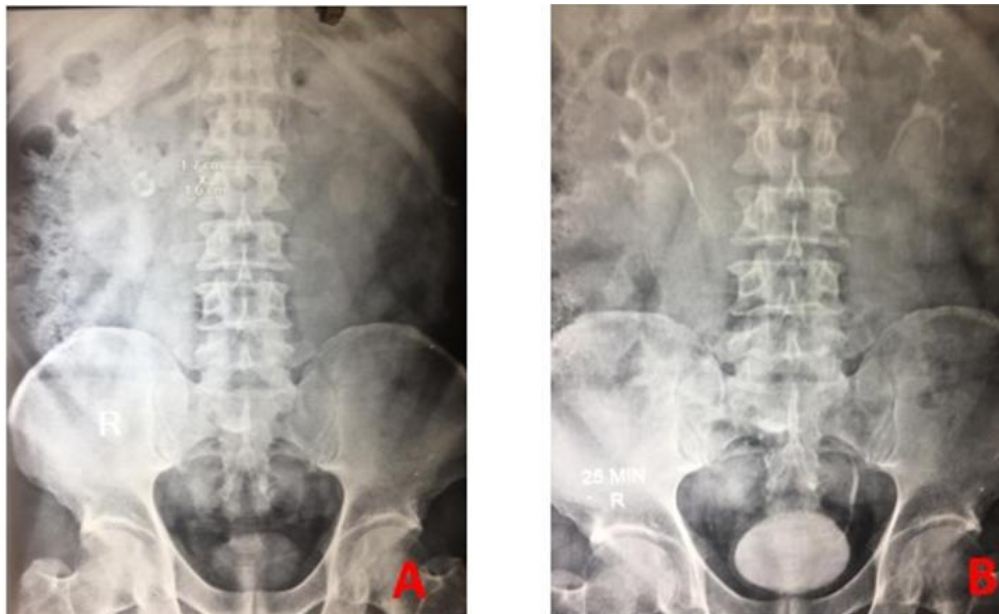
A) Plain Xray KUB showing “ring-like” calcification in right renal area B) IVU showing bilateral normally functioning kidneys with ring-like calcification opposed to the right renal pelvis
